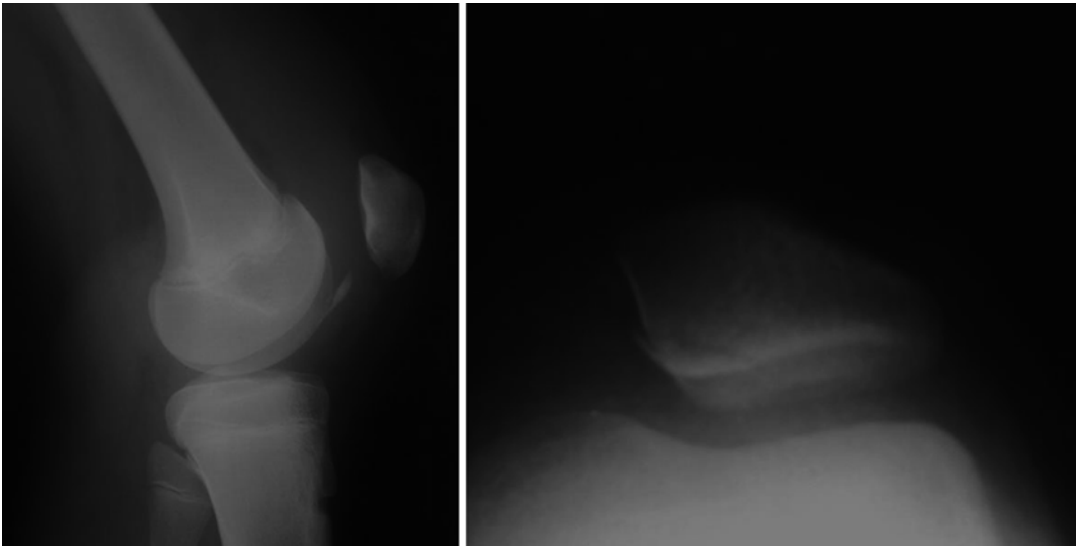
Lateral and skyline radiographs showing an osteochondral fragment originating from the patella lying anteriorly to the femoral condyles (*left*) and a coronal fracture of the patella (*right*)
